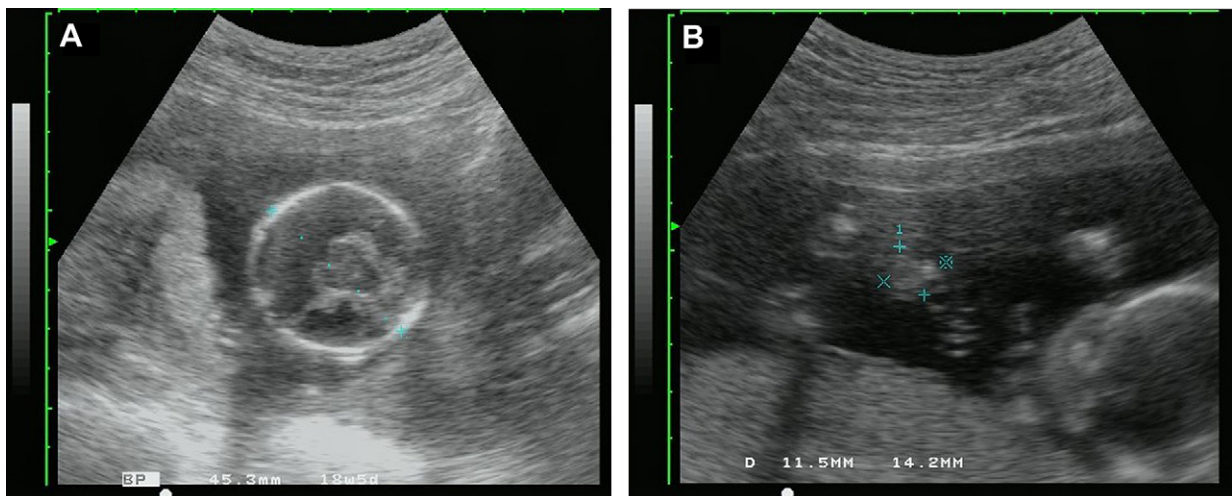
Prenatal ultrasound of Case 5 at 17 gestational weeks shows (A) alobar holoprosencephaly and (B) a small omphalocele.
